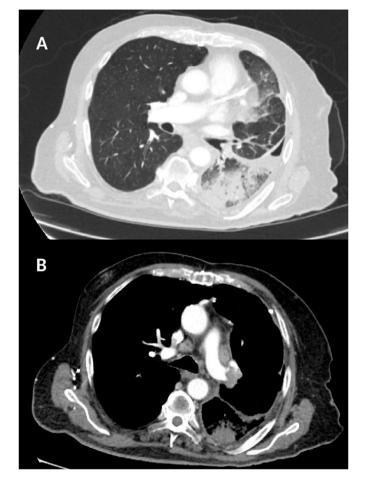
On admission, computed tomography of the chest showed (A) left lung infiltrate, and (B) pleural calcifications and mediastinal adenopathy. Lung window settings: thickness 1mm, width 1600.
